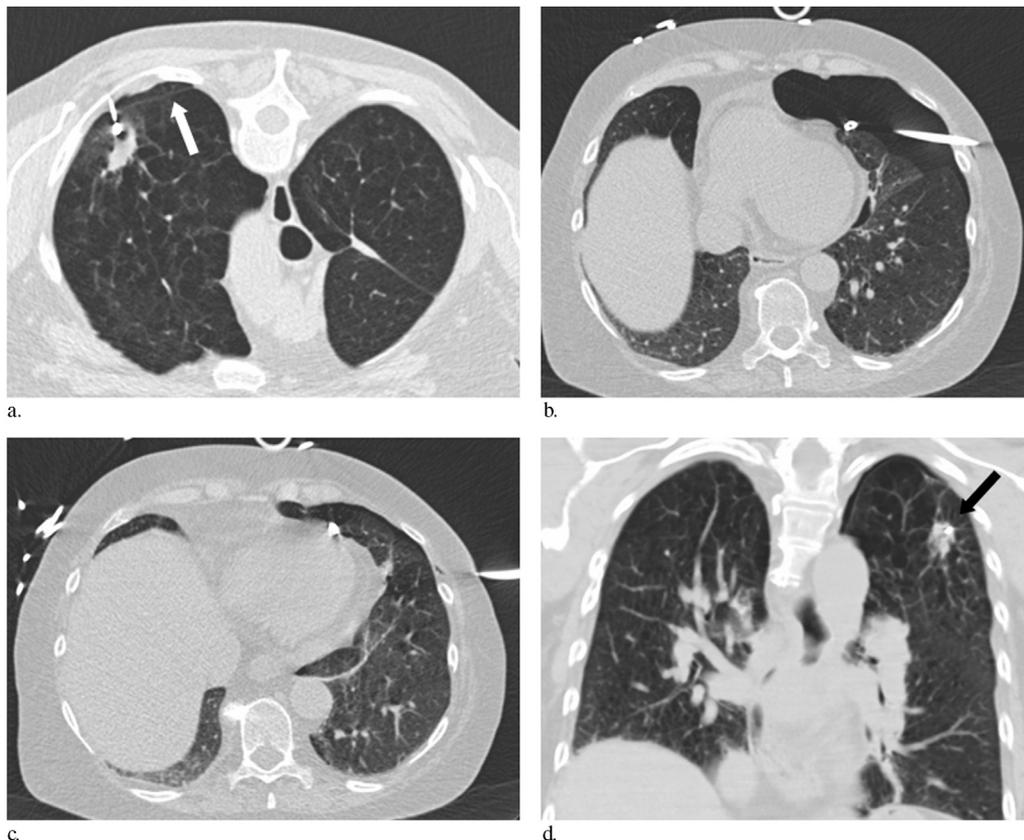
Images from a 66-year-old woman with COPD, a history of non–small-cell lung cancer, and a new tumor in the left upper lobe. One fiducial seed is inserted into the tumor under CT fluoroscopic guidance with crossing of the fissure (arrow) in prone position of the patient (a). Although the initial control CT scan did not show a marked pneumothorax, a few minutes after the procedure, severe dyspnea developed and the patient was intubated by the anesthesiologists. Under CT fluoroscopy, a tension pneumothorax was confirmed and immediately treated by insertion of a 14-F pigtail drainage in supine position (b), which relieved the pneumothorax instantly (c). The final CT scan confirmed a correct intratumoral localization of the fiducial seed (d) (arrow).
